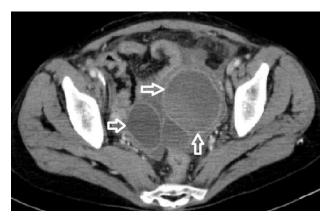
Axial contrast-enhanced CT shows tubo-ovarian abscesses on the left side of the adnex (arrows)
